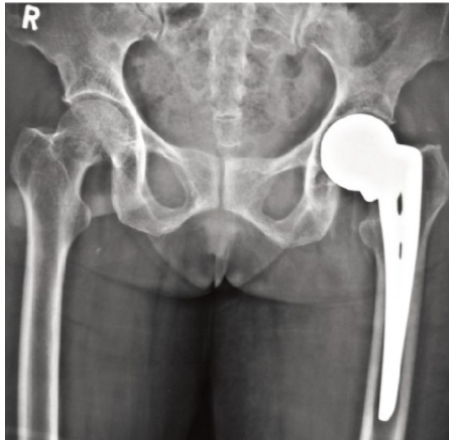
Showing AP radiograph of patient operated with Unipolar Hemiarthroplasty.
